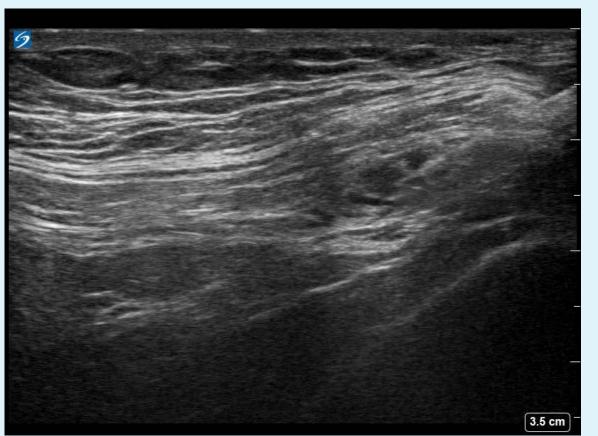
Ultrasound image showing anatomy prior to IL/IH block. Figure 2b: Ultrasound image with false color overlay showing anatomy prior to IL/IH block.
